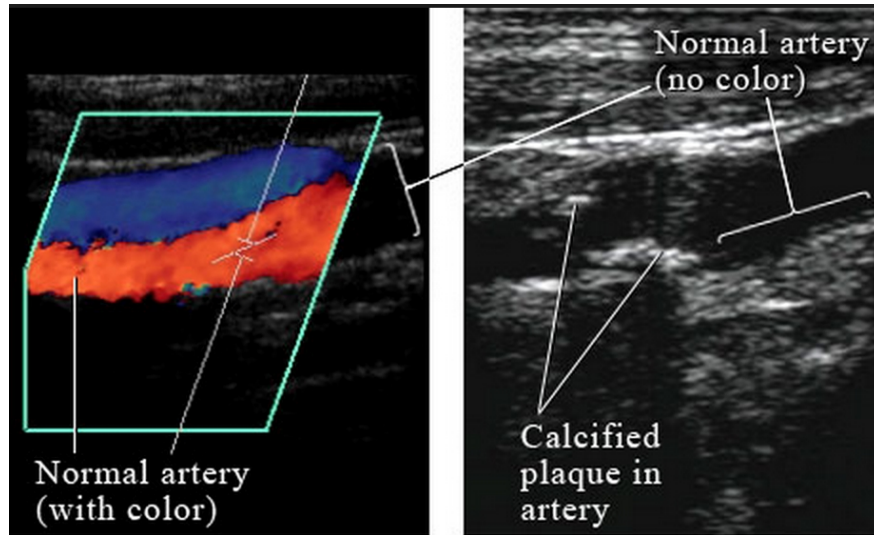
The image left is color coded Doppler US on top of B-mode image which stays on right side [7].
